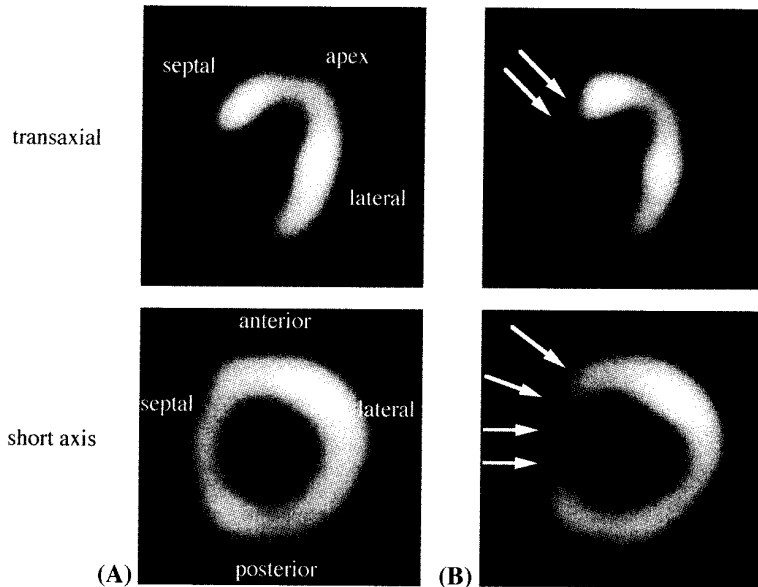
Case 2. ^{201}Tl myocardial scintigrams at rest (A) and after dipyridamole infusion (B), showing a reversible perfusion defect in the anteroseptal wall.
